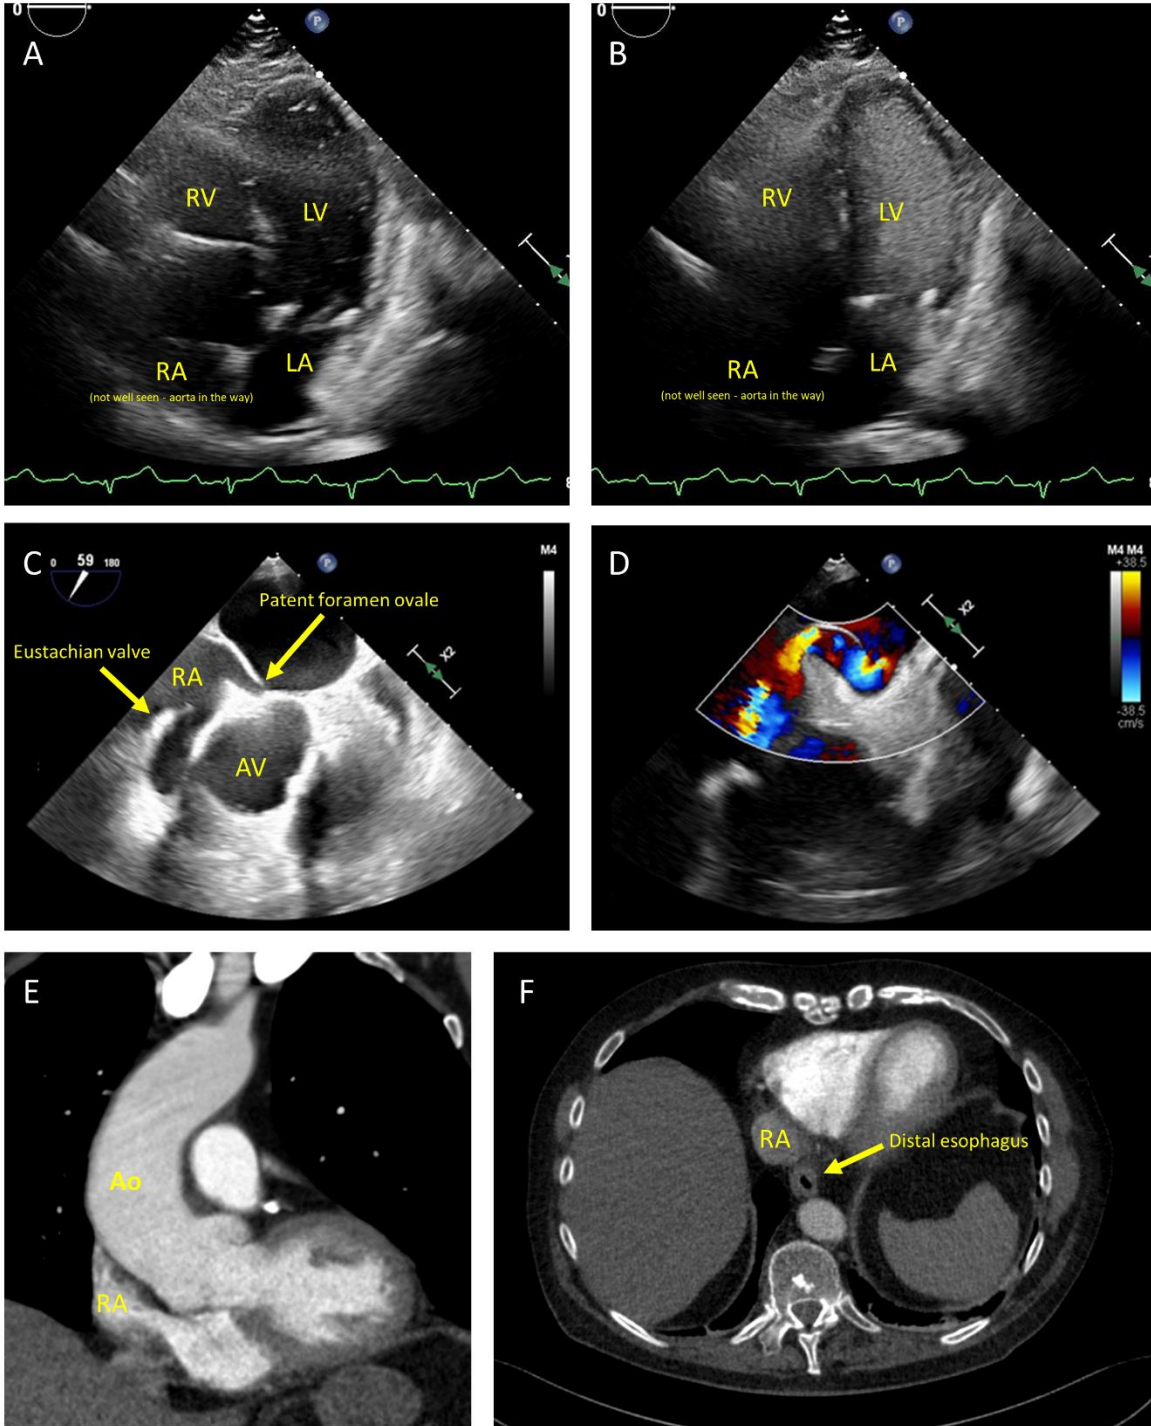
Transthoracic echocardiogram with agitated saline contrast (A & B) showing left-sided chamber opacification, suggesting a right-to-left intracardiac shunt. A transesophageal echocardiogram (C & D) confirming a patent foramen ovale with a prominent Eustachian valve directing the flow to the atrial septum, with a large right-to-left interatrial shunt. Computed tomography showed a dilated and tortuous aorta resulting in a distorted cardiac axis (E) with the distal esophagus in close proximity relative to a small and compressed right atrium (F).
